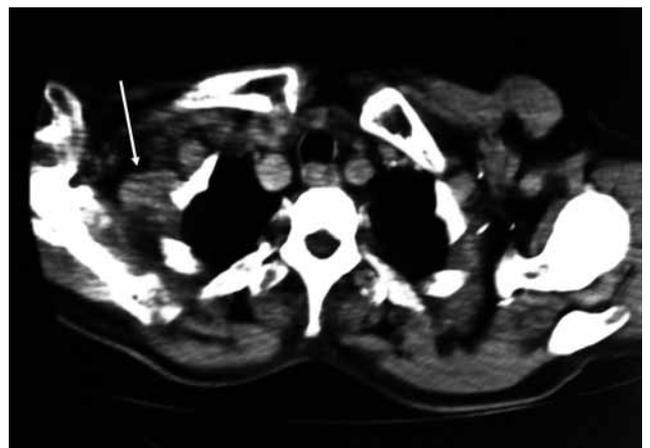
Preoperative computed tomographic view of a patient with an aneurysm in the right axillary artery. The arrow indicates the aneurysm.
